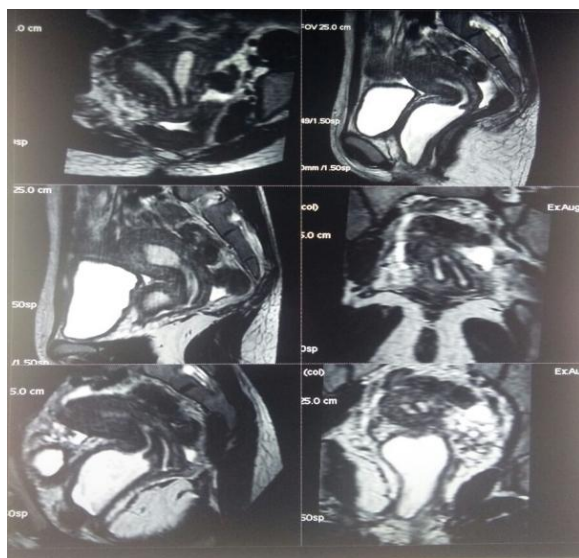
MRI showing the absence of uterus didelphys + hematocolpos
